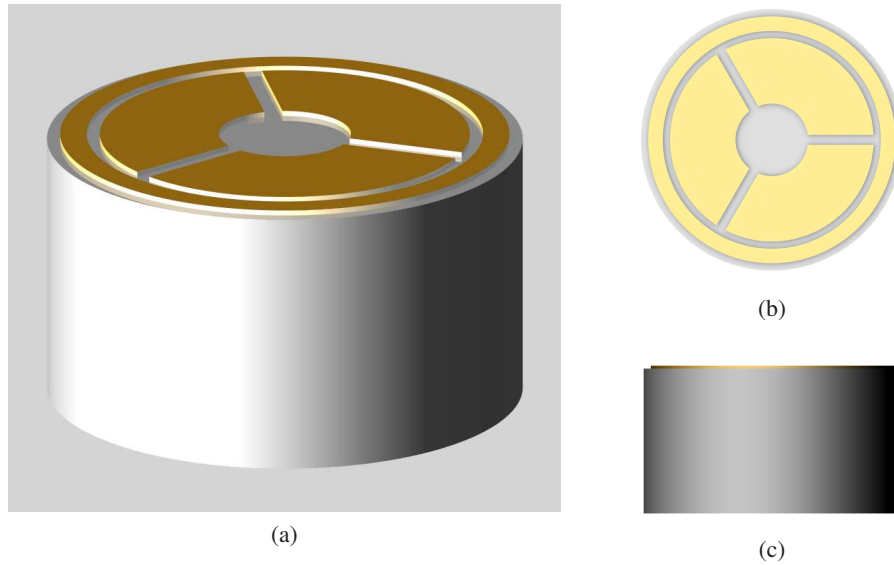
Design and basic arrangement of the transducer elements within the ultrasound probe (rendered CAD depiction).
